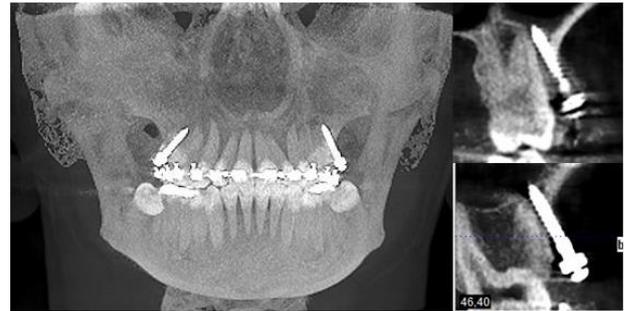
OBS miniscrew CBCT images placed in infrazigomatic crest
